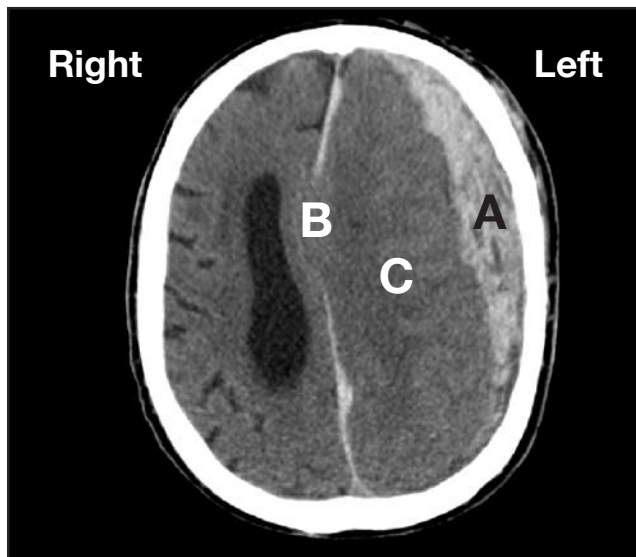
The CT scan shows a large left-sided, subdural haematoma (A). There is also left-to-right midline shift (B), due to the haematoma and oedema of the left cerebral hemisphere (C).
